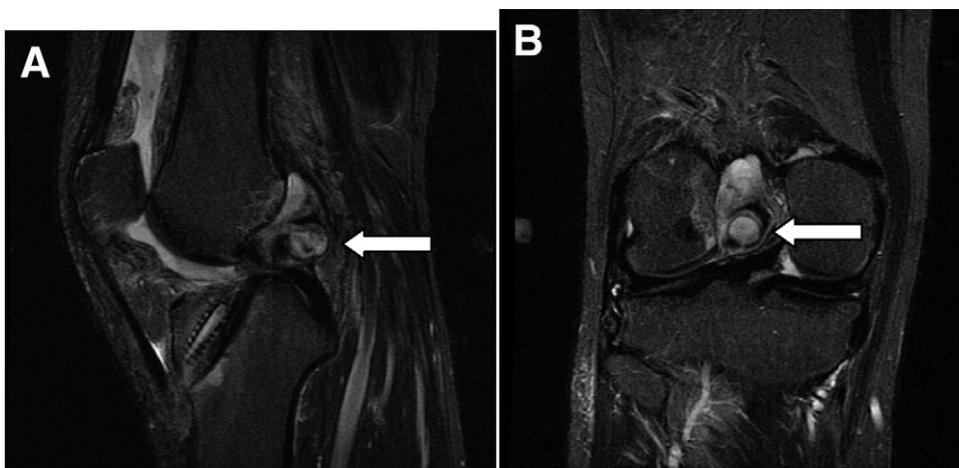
T2-weighted magnetic resonance images with fat saturation of right knee, showing cyst posterior to ACL graft (arrows), both on (A) sagittal and (B) coronal sections.
